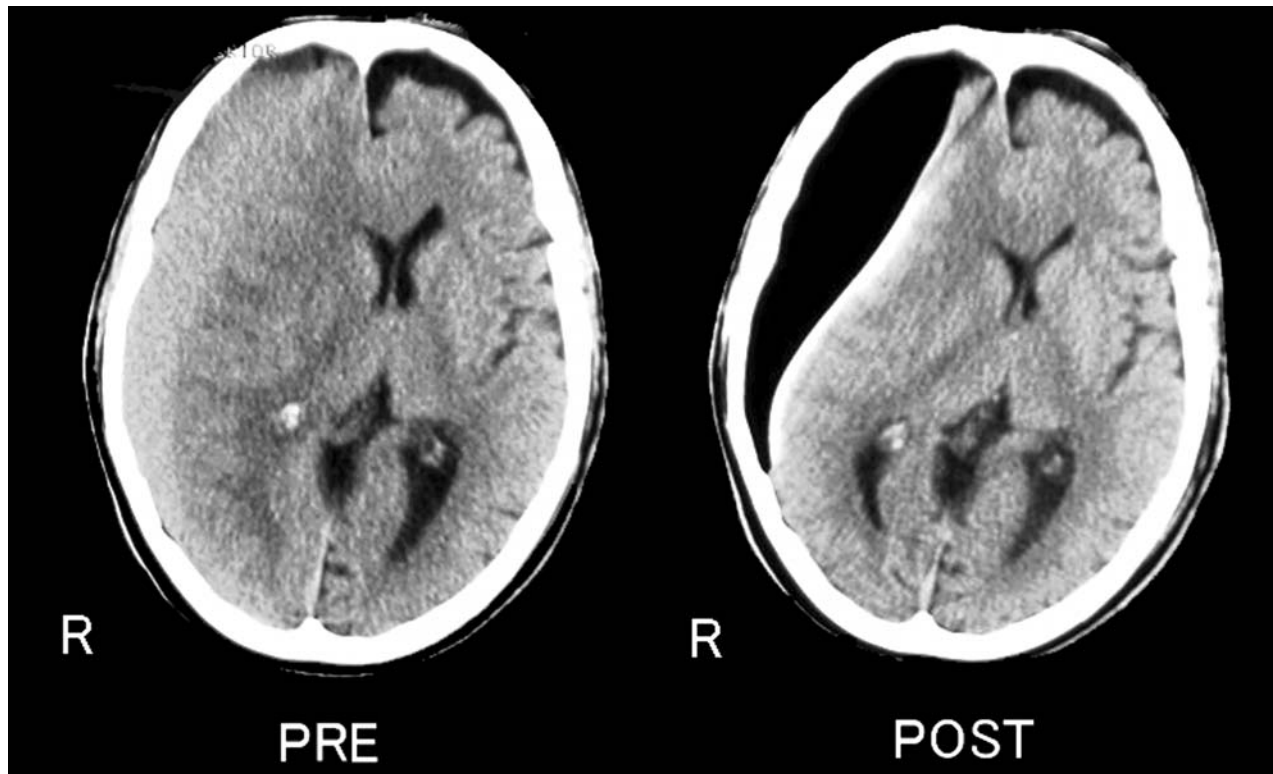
Typical CT scans of this type of surgery. The CSDH almost changed to oxygen
